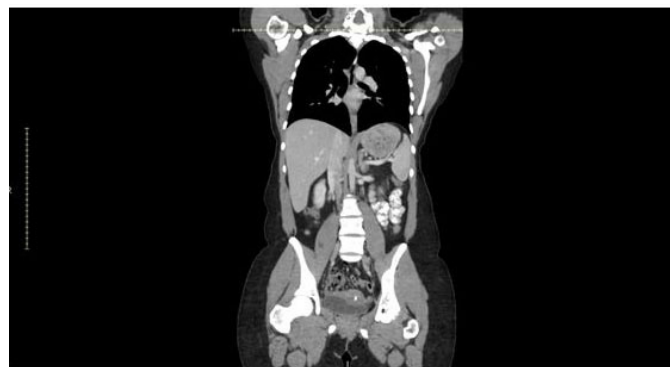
CT scan of the chest six months after completion of cancer treatment showing complete remission.
